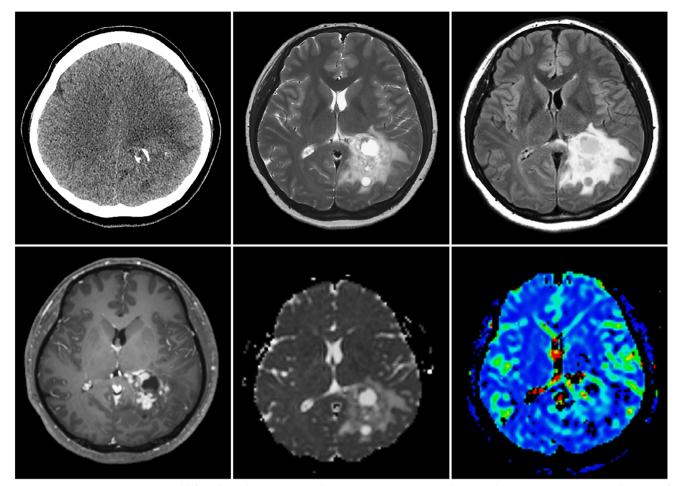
Images in a 29-year-old female with extraventricular neurocytoma. On CT, there is a low-attenuating mass with areas of calcification at the left parietal lobe. On MRI, the mass also involves the left temporooccipital lobe with moderate edema. The mass is well-defined, with multiloculated cystic and solid appearance and enhancement at the solid portion. There are foci of slight cellularity increase on ADC map and mild rCBV increase.
